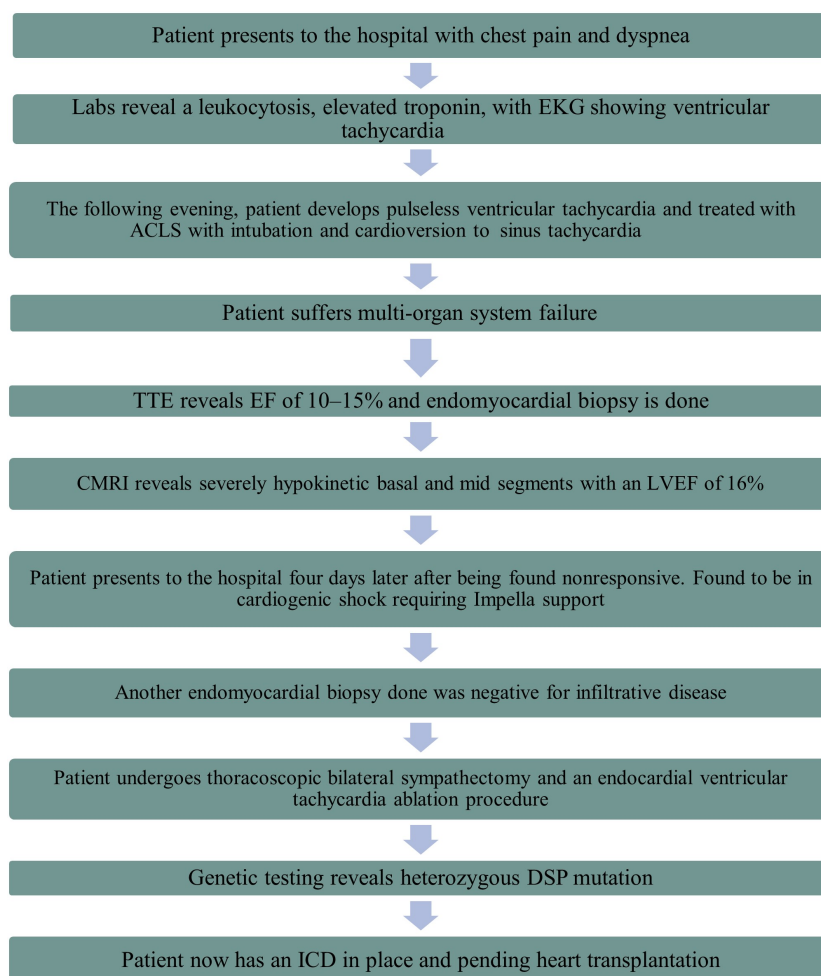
Timeline of events. ACLS: advanced cardiovascular life support; TTE: transthoracic echocardiogram; CMRI: cardiac magnetic resonance imaging; LVEF: left ventricular ejection fraction; DSP: desmoplakin; ICD: implantable cardioverter defibrillator
